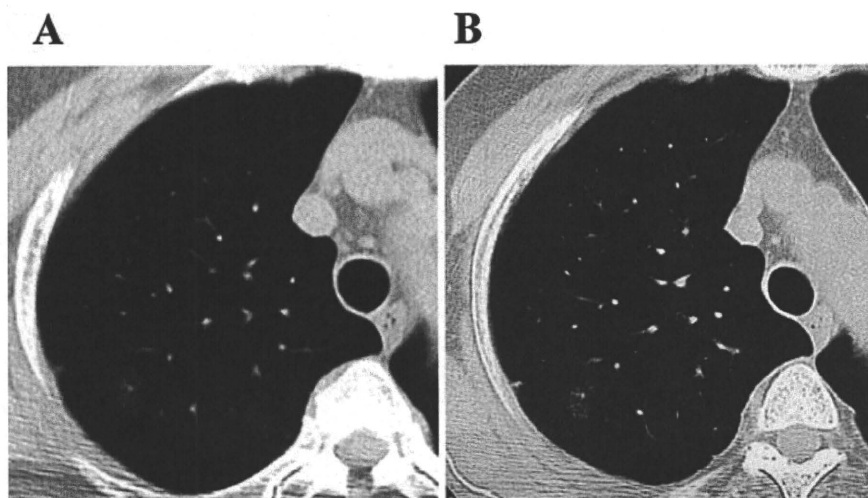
Computed tomography (CT) image of a representative case of a small lung lesion. The 68-year-old woman was available for long-term follow-up. A Thin-section CT scan of a 10-mm diameter tumor in the right upper lung lobe with pure ground-glass opacity (GGO), an indistinct boundary, and hazy attenuation. B The size of GGO was unchanged at the 27-month follow-up. The lesion size either did not change or increased only slightly (up to 5 mm) in 9 of 13 GGO patients who we observed for more than 2 years
